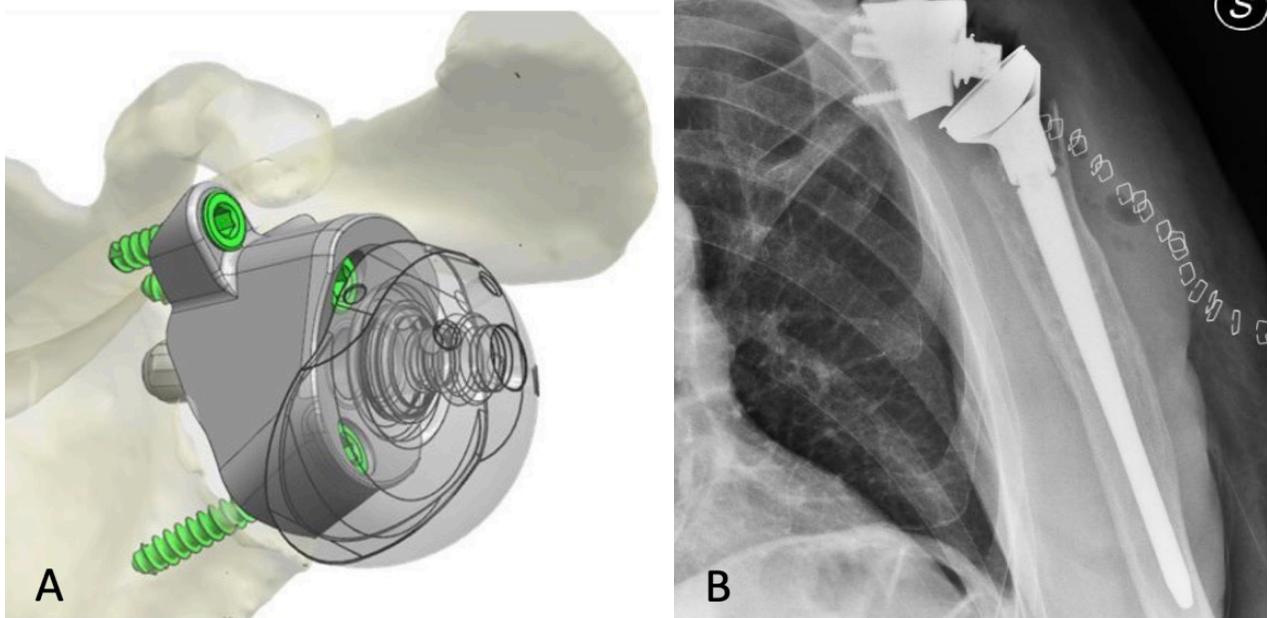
Reverse total shoulder arthroplasty with custom glenoid component for severe glenoid bone deficiency (Promade, Lima, San Daniele del Friuli, Italy). A, Preoperative implant configuration of screws and baseplate position using 3D computed tomography model; B, Postoperative X-ray.
